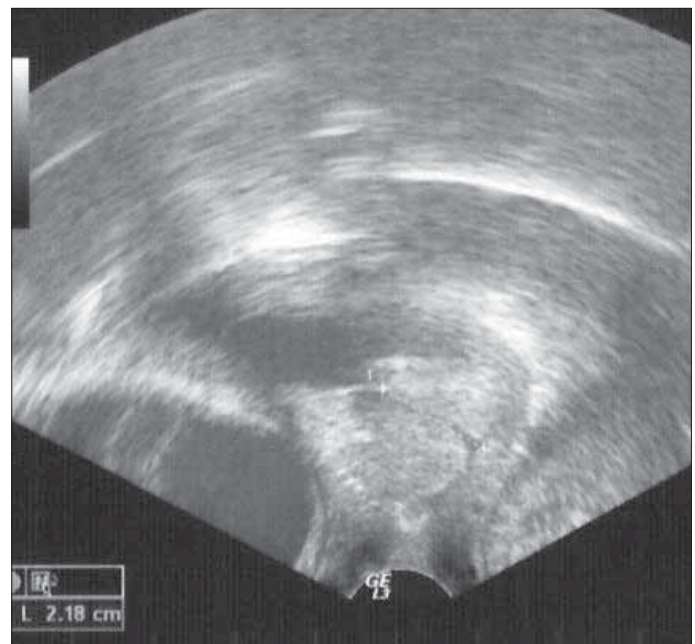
Postcerclage ultrasound measurement of cervical length in case 2 (2.18 cm)
